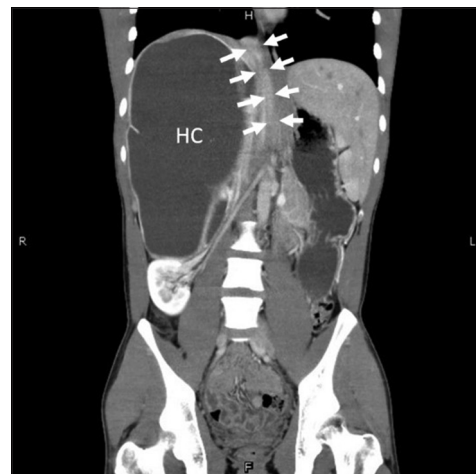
Coronal computed tomographic image showing giant hepatic cysts with partial compression of the inferior vena cava (arrows)
